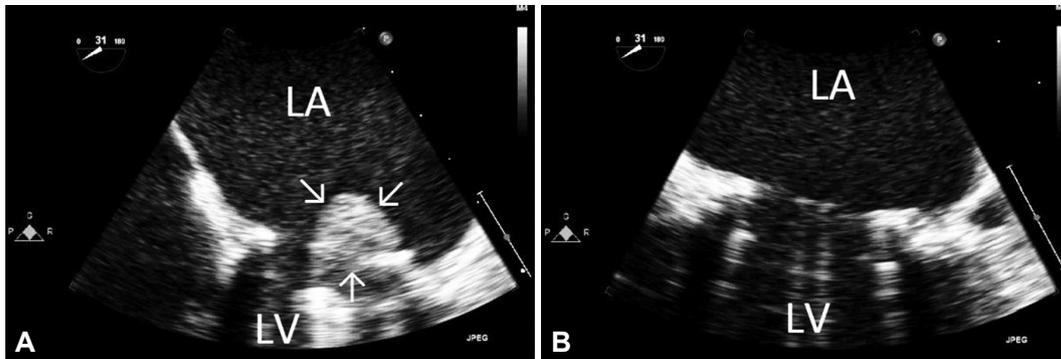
Transesophageal echocardiography demonstrates the prosthetic valve thrombosis (arrows) (A). The thrombus is successfully lysed by low dose slow infusion of tissue-plasminogen activator (B). LA: left atrium, LV: left ventricle.
